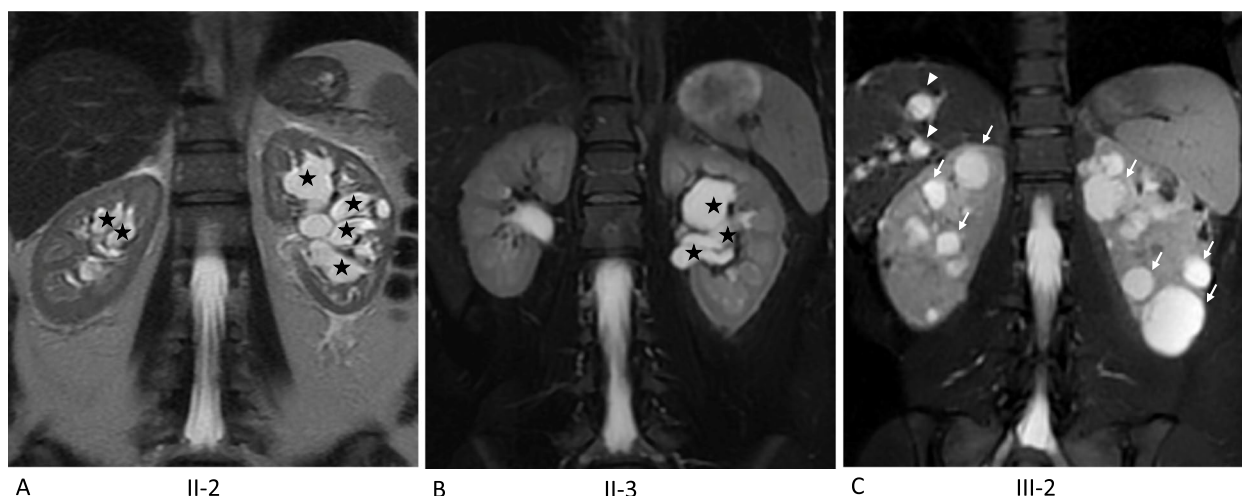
Comparative MRI Findings in Patients with Parapelvic (Patients II-2 & II-3) vs ADPKD (Patient III-2). Coronal T2-weighted fat-suppressed (fat sat) MRI images demonstrate the presence of bilateral parapelvic cysts (black stars) without any accompanying cortical cysts in Patients II-2 (A) and II-3 (B). In contrast, coronal T2-weighted fat-suppressed MRI images for Patient III-2 reveal bilaterally enlarged kidneys, multiple cortical cysts (white arrows), and associated liver cysts (white arrowheads) (C)
